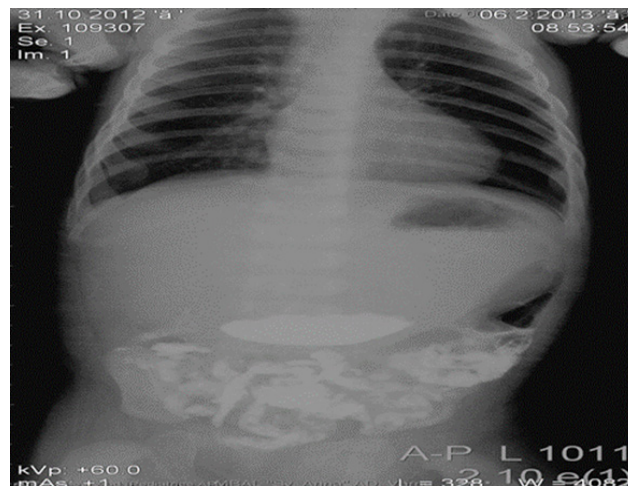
The contrast material depot persisted comparatively to the result of the previous X-ray.
